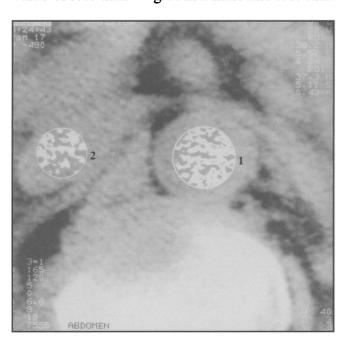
CT of the abdomen at the level of the superior mesenteric artery (SMA): Regions of Interest (ROI) defined within the lumina of the aorta (1) and the inferior vena cava (2).
